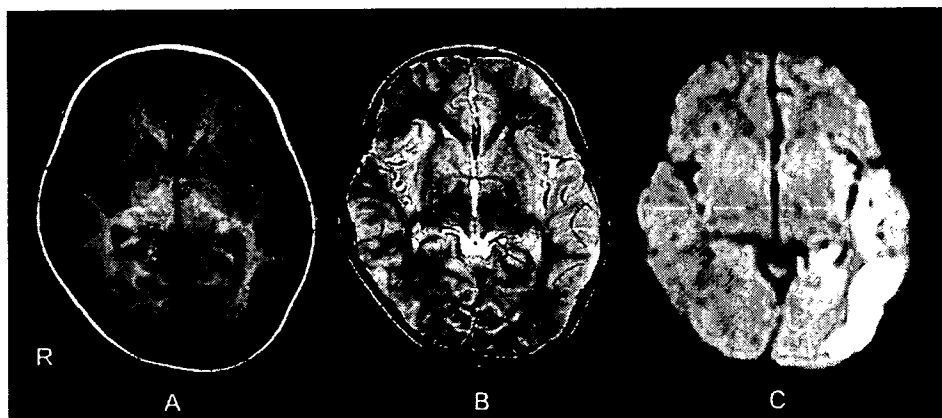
Neuroradiologic findings of patient 6: magnetic resonance imaging 9 days after onset. Subtle thickening of the cortex in the left temporo-parieto-occipital area was seen on  $T_1$ -weighted (A: fast spin-echo, TR/TE = 596/15 ms) and  $T_2$ -weighted (B: fast spin-echo, TR/TE = 4162/100 ms) images. Diffusion-weighted images (C: spin-echo echo-planar imaging, TR/TE = 2835/89 ms,  $b = 1000 \text{ sec/mm}^2$ ) demonstrated marked high intensities in the same region.
